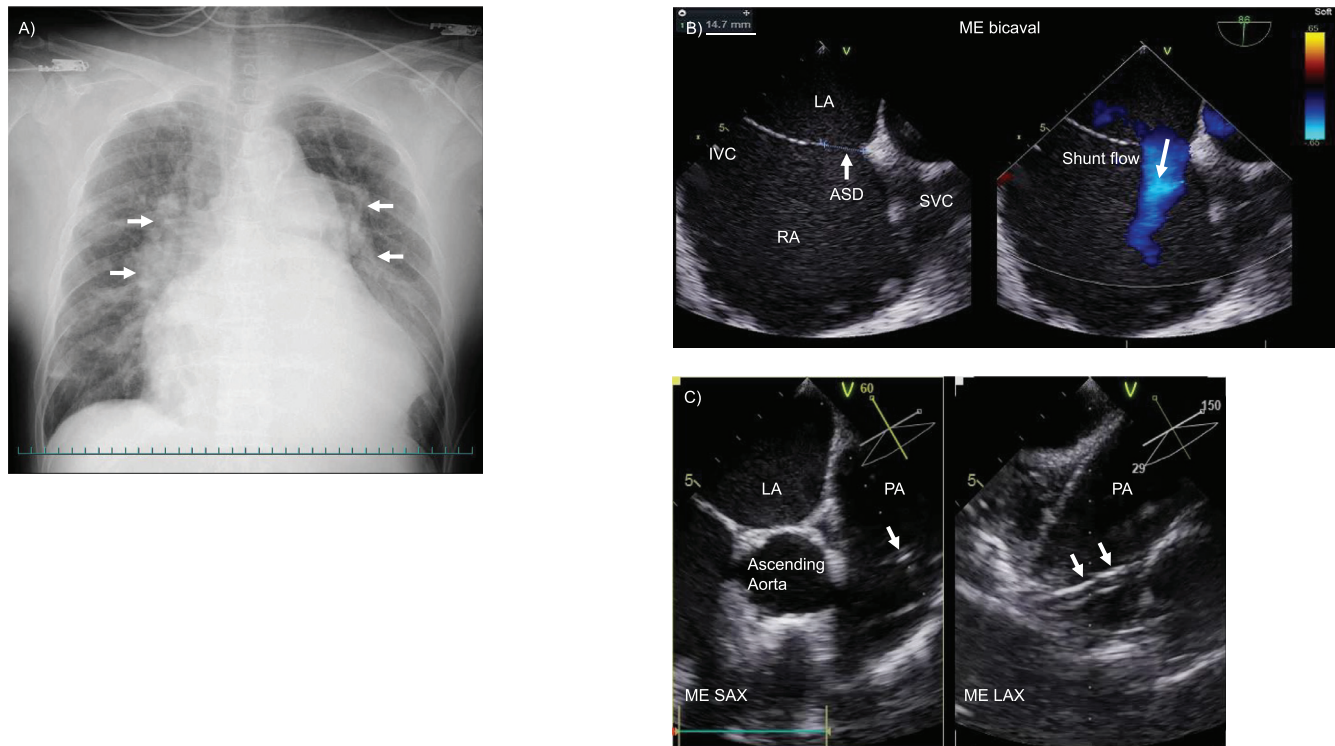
(A) Chest radiograph demonstrating cardiomegaly, diffuse bilateral pulmonary opacities (arrows), and bilateral pleural effusions. (B) Transesophageal echocardiography (TEE), mid-esophageal (ME) bicaval view, demonstrating a 14.7-mm secundum-type atrial septal defect (ASD): 2-dimensional image showing ASD diameter measurement (left) and color Doppler imaging demonstrating left-to-right shunt flow (arrow, right). (C) A 15-Fr cannula (arrows) inserted into the main pulmonary artery (PA), visualized on intraoperative TEE. The probe angle was adjusted to optimize visualization of the PA cannula; therefore, the long-axis (LAX) image differs slightly from the conventional ascending aortic long-axis view. IVC, inferior vena cava; LA, left atrium; RA, right atrium; SAX, short-axis; SVC, superior vena cava; V, velocity.
